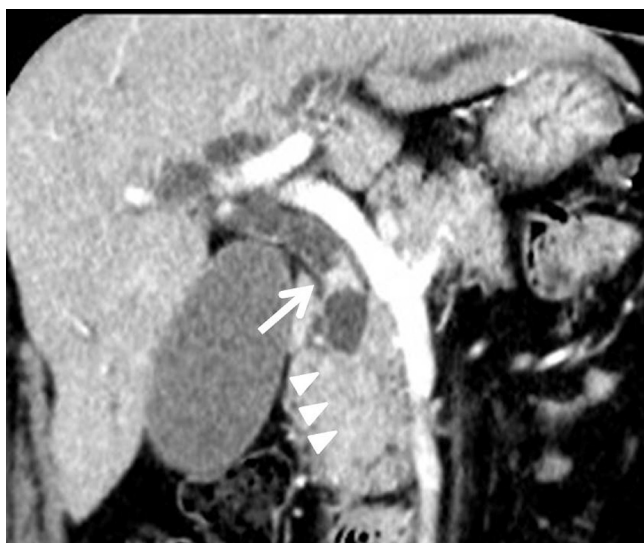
Coronal image of contrast-enhanced computed tomography of the abdomen. The common bile duct wall in the junction of cystic duct is thickened (arrows). The common bile duct does not trace until the papilla of Vater, which suggests that there is stenosis in the distal bile duct (arrowheads).
